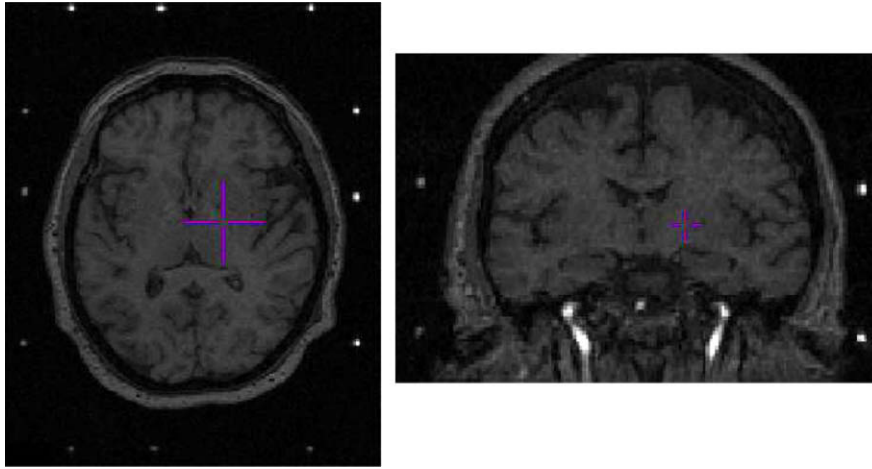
Example of pre-operative MRI volume with head-frame affixed to patient. (Left) Sagittal view; (middle) coronal view; (right) axial view. Image volume shows lack of contrast in the sub-cortical nuclei. Surgical targeting is extremely difficult in these nuclei as a result.
